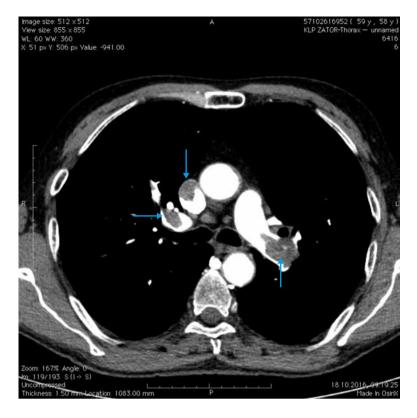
Computed tomography angiography of pulmonary arteries, revealing massive pulmonary embolism to avoid hemorrhagic complications.^{2.3} Importantly, the history of rVIIa supplementation without thrombotic complications does not exclude the possibility of thrombotic complications in the future. Several such cases have been reported by Girolami et al.⁴ Our case was complex and untypical in that the patient had cancer and suffered from massive bleeding that required urgent surgery. Both these factors significantly increase the thrombotic readiness and the risk of PE. In our opinion, rVIIa administration might have been one of the many causes of PE.⁵ Therefore, in such extreme cases, the use of rVIIa must be weighed against the expected benefits.
